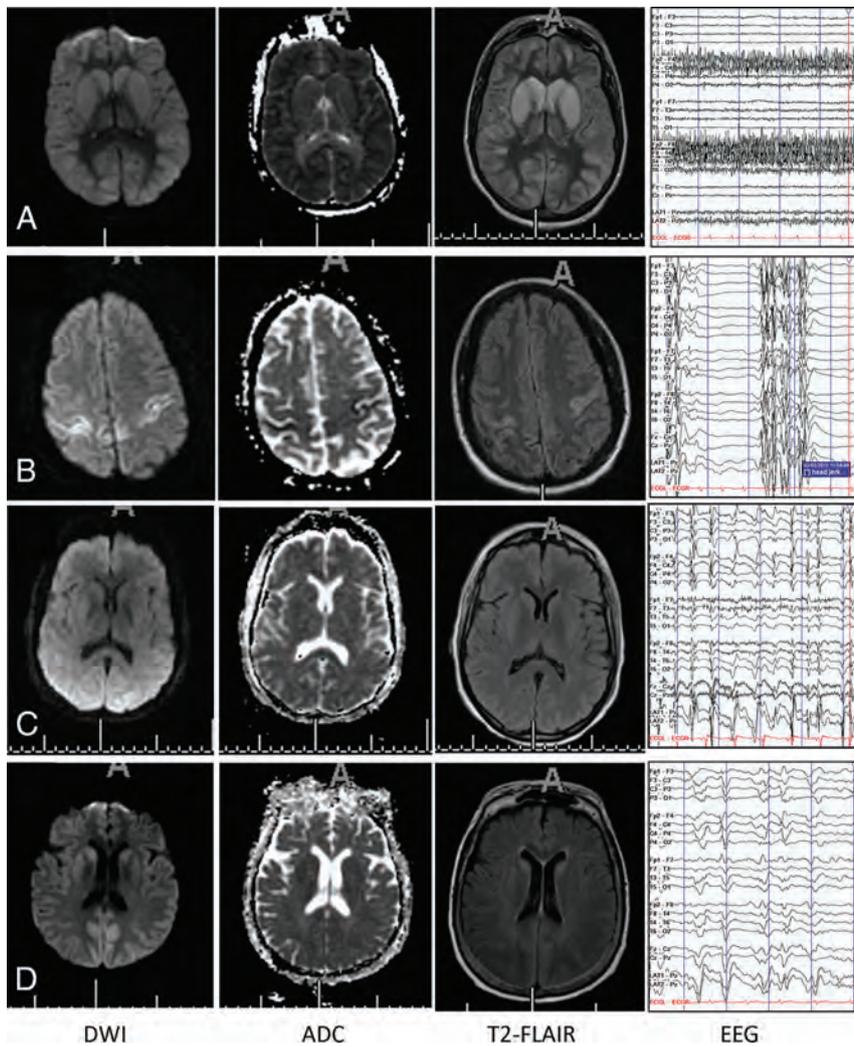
Selected examples of patterns of DWI, ADC, and T2-FLAIR abnormalities in subjects without (A) and with (B–D) malignant EEG patterns (longitudinal bipolar montage [low-frequency filter, 1 Hz; high-frequency filter, 70 Hz; 60-Hz notch on; sensitivity, 7 μ V/mm]). All of these subjects had bad outcomes (death, coma, or persistent vegetative state at discharge). A, Diffuse gyral edema and restricted diffusion, wbADC = 666×10^{-6} mm²/s. EEG (nonmalignant) pattern of diffuse background slowing. B, Focal diffusion abnormality involves the sensorimotor cortices, wbADC = 835×10^{-6} mm²/s. EEG demonstrates a (malignant) suppression burst pattern. Bursts are associated with clinical jerks. C, Essentially normal MR imaging appearance of the brain, wbADC = 782×10^{-6} mm²/s. EEG demonstrates a (malignant) pattern of generalized periodic discharges. D, Posterior (parietal) diffusion abnormality with little gyral edema, wbADC = 824×10^{-6} mm²/s. EEG (malignant) pattern of GPDs.
